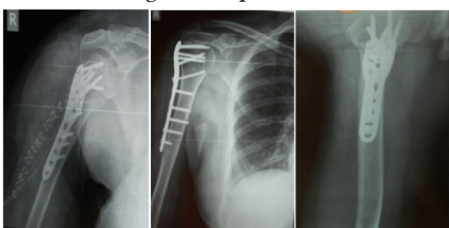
post op x-rays fig5: follow up after 6 month
